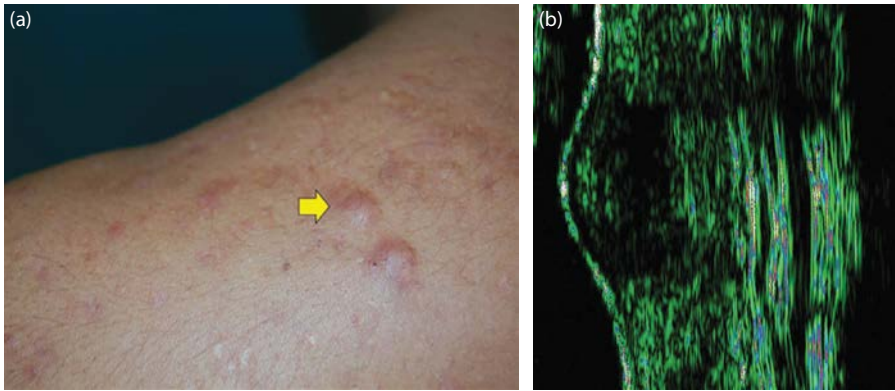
Hypertrophic scar: (a) clinical and (b) ultrasound appearance.
